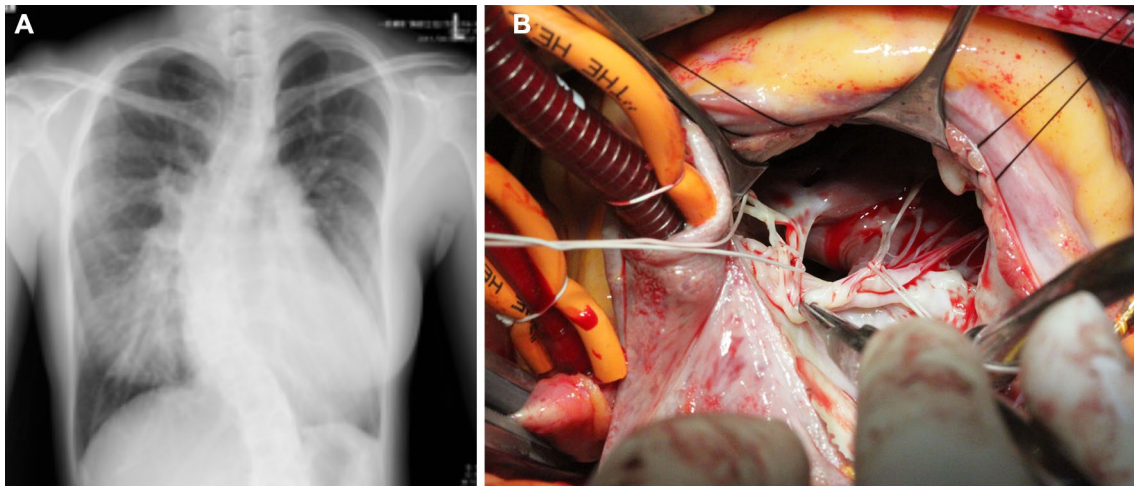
a Chest X-ray of a 35-year-old woman. CTR was 65%. VSD with severe PAH. Preoperative PAp was 112/23 (mean 59) mmHg and PVR was 11 WU. After O₂ inhalation, PVR decreased to 6.7 WU. b Intraoperative photo of the patient. Large perimembranous VSD, of which diameter was 15 mm, was closed with a patch. Oral
